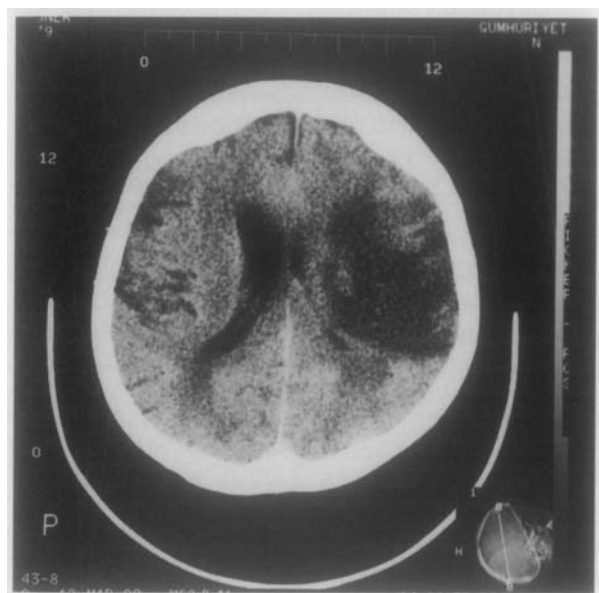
CT showing infarct in the left hemisphere
